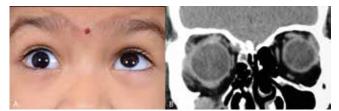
(A) Right upgaze restriction after blunt trauma (B) Coronal CT shows right orbital floor fracture with incarceration of the inferior rectus muscle in the fracture.
